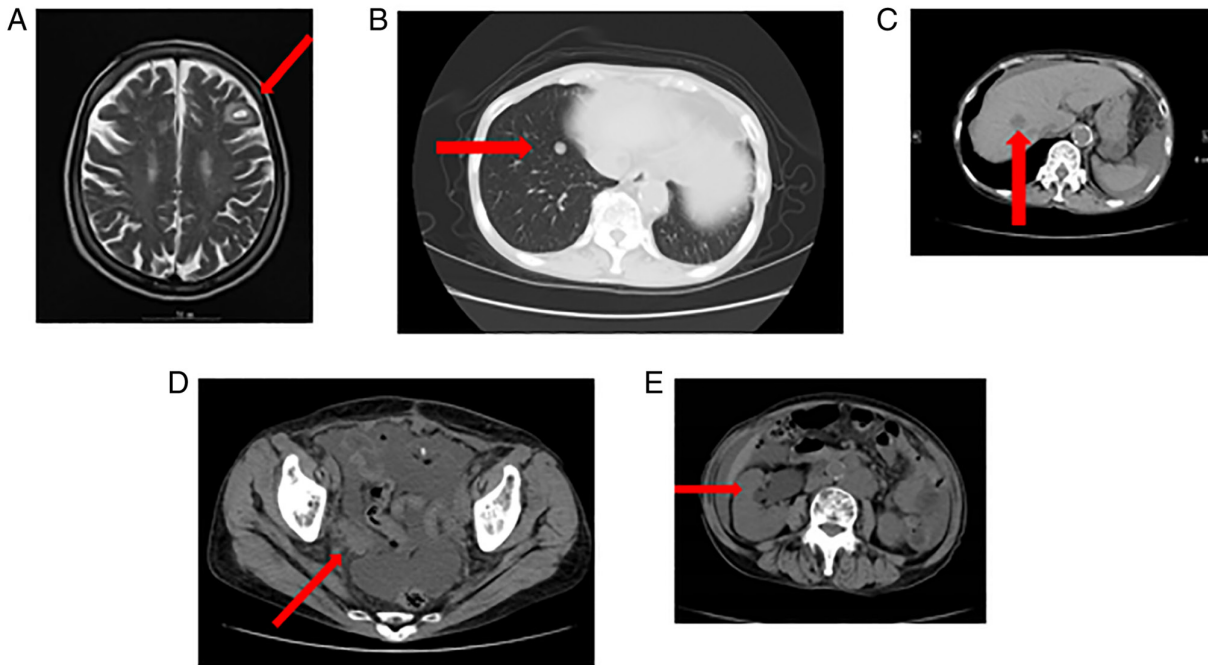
Recurrent findings in this case before and after nivolumab administration. (A) Magnetic resonance imaging findings of brain metastasis before nivolumab administration. (B) The findings of lung metastasis on CT images after nivolumab administration. (C) The findings of liver metastasis on CT images after nivolumab administration. (D) The findings of pelvic metastasis on CT images after nivolumab administration. (E) The findings of hydronephrosis on CT images after nivolumab administration. The lesions are indicated by red arrows. CT, computed tomography.
